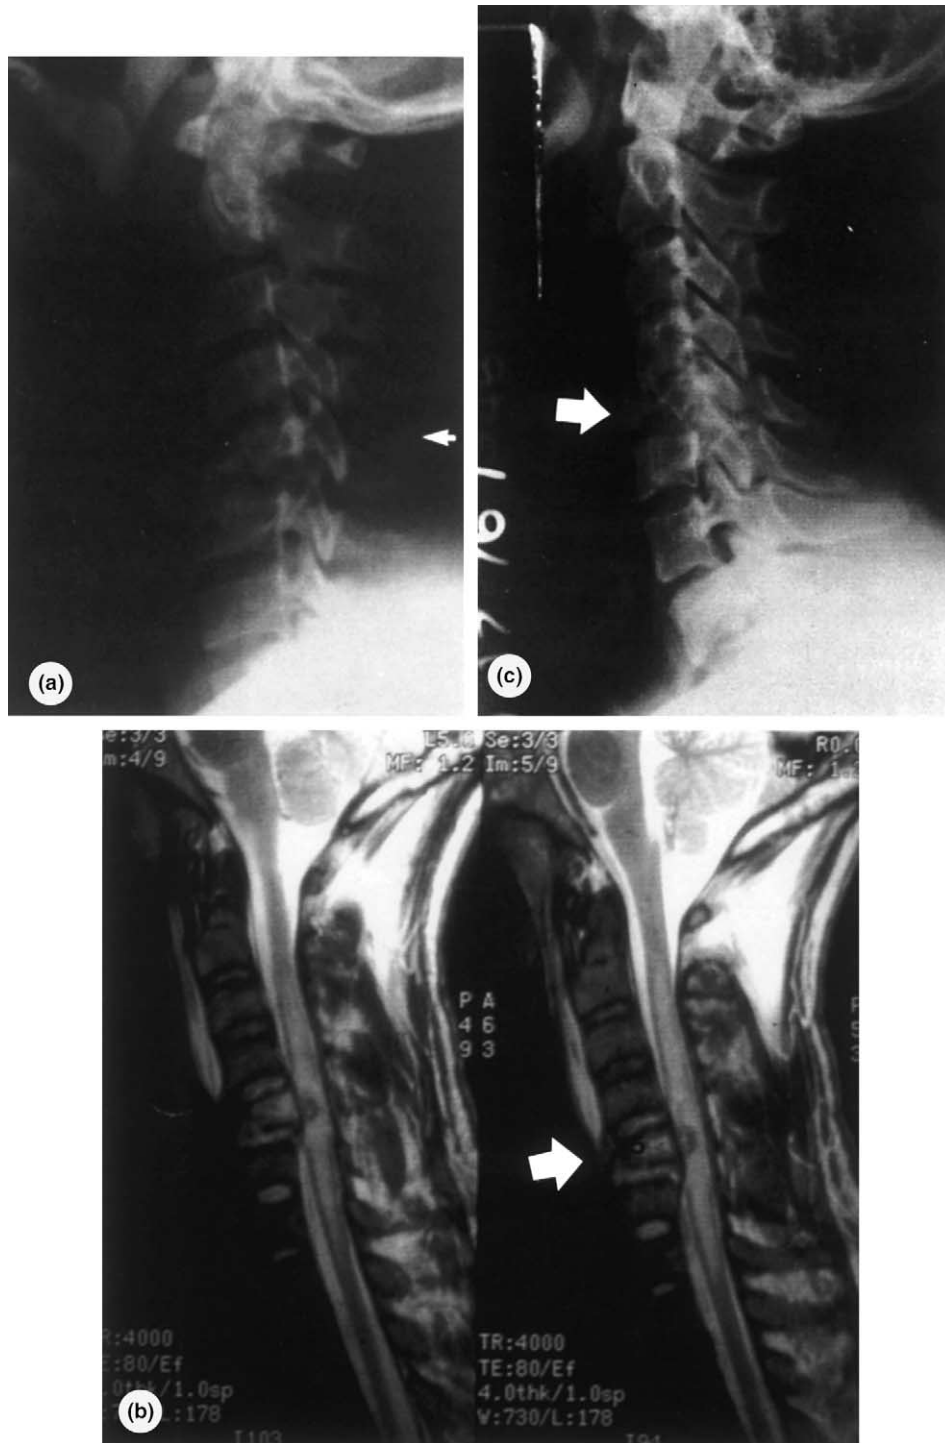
(a) Lateral cervical radiograph of a compressive fracture of C5 with minimal retropulsion into the spinal canal. Arrow shows widening of the interspinous ligamentous complex (fanning); (b) sagittal MR showing the presence of small epidural hematoma (arrow) and mild canal compromise; and (c) lateral cervical radiograph showing burst (comminuted) fracture of C5 with retropulsion of fragments into the canal. The principal axial force does not compromise the posterior ligamentous complex.
